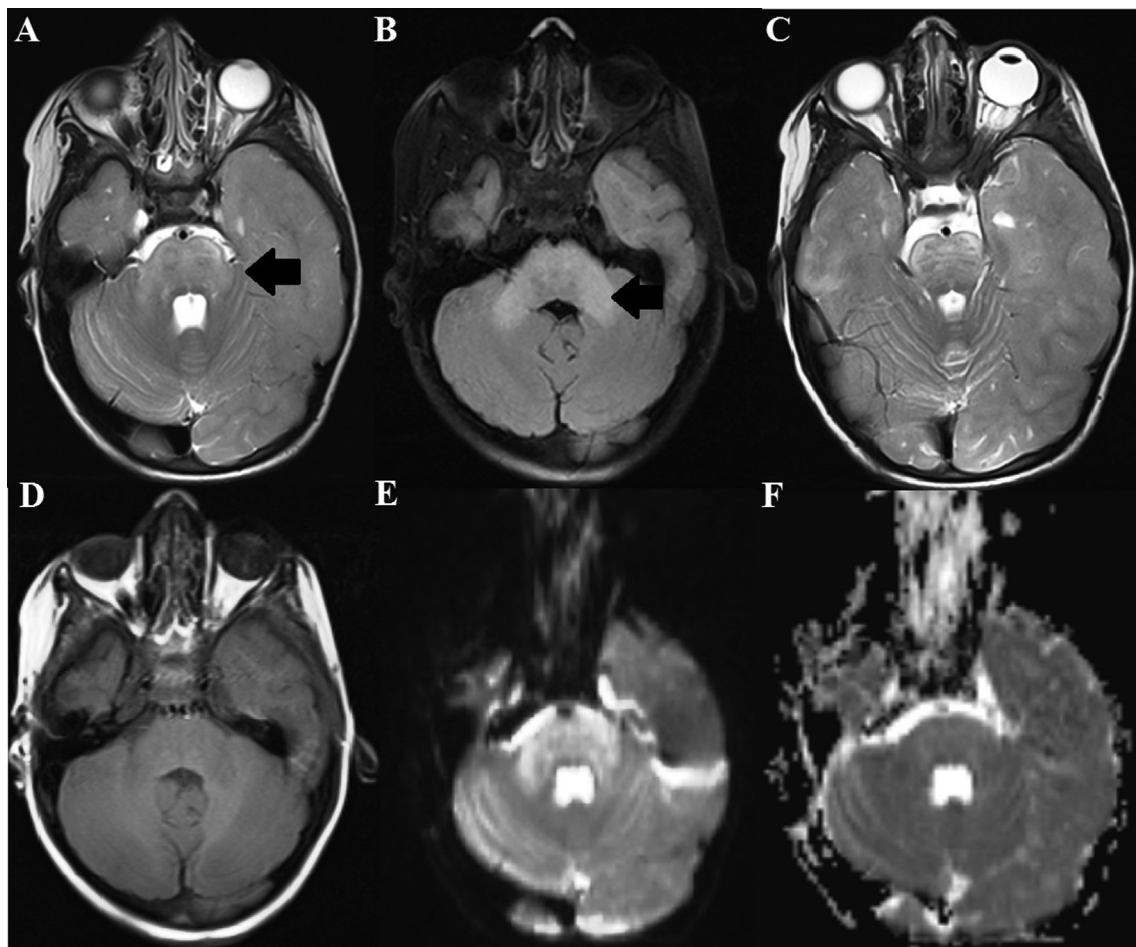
Axial T2-weighted (A and C) and fluid-attenuated inversion recovery (B) MRI images showing hyperintense lesion in the pons and middle cerebral peduncles (A and B, arrows). There is also involvement of ventral midbrain (C). The lesions are hypointense on T1-weighted images (D). Diffusion restriction is seen in the pons and middle cerebral peduncles (E, diffusion weighted image with $b = 1000$ and F, apparent diffusion coefficient image).
